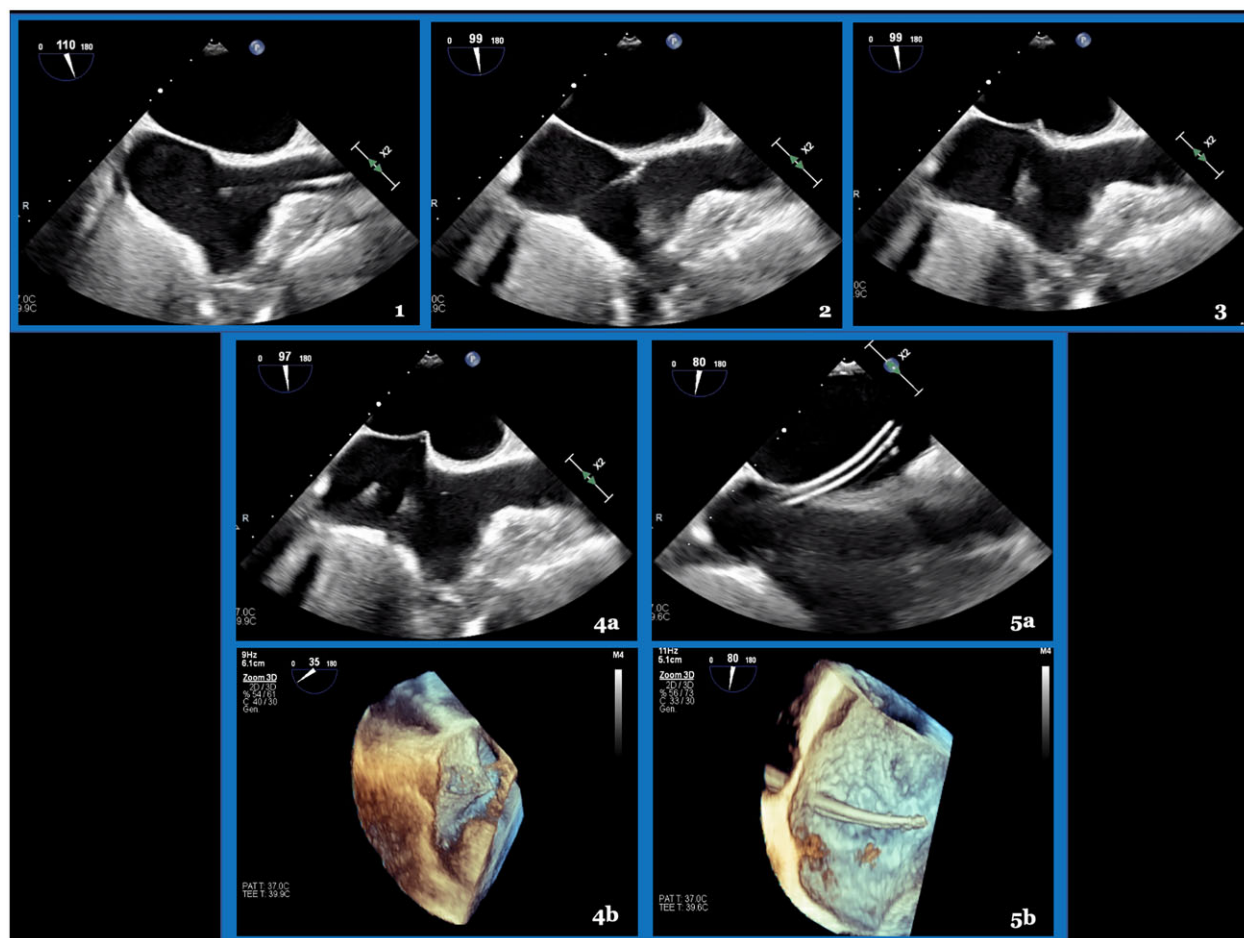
Transeptal puncture with bidimensional and tridimensional transesophageal echocardiographic assistance. From the bicaval view, the transeptal needle is initially positioned in the lower part of superior vena cava (Panel 1), then, is slowly pulled down (Panel 2) until it reaches the true fossa ovalis (Panel 3); in this position, the position of the needle is slightly adjusted until tenting is visualized (Panel 4A and 4B). Then, after achieving the ideal position of the needle, the transeptal needle is advanced until passing through the interatrial septum to the left atrium (Panel 5A and 5B).
